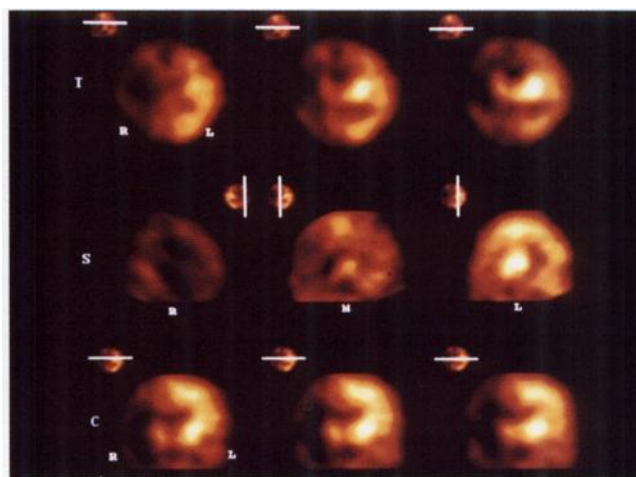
Diffuse decrease in rCBF in ipsilateral hemisphere (Patient 4). Note marked decrease (75%) in rCBF within the right cerebral hemisphere on transverse, sagittal and coronal slices. US showed only mild ventricular dilatation with an interhemispheric fluid collection which is also seen on transverse SPECT slices.
